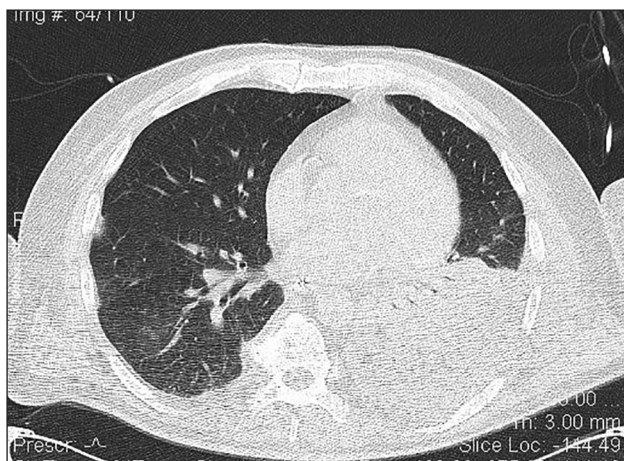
Computed tomography of the thorax — opacity in the left lower lobe
